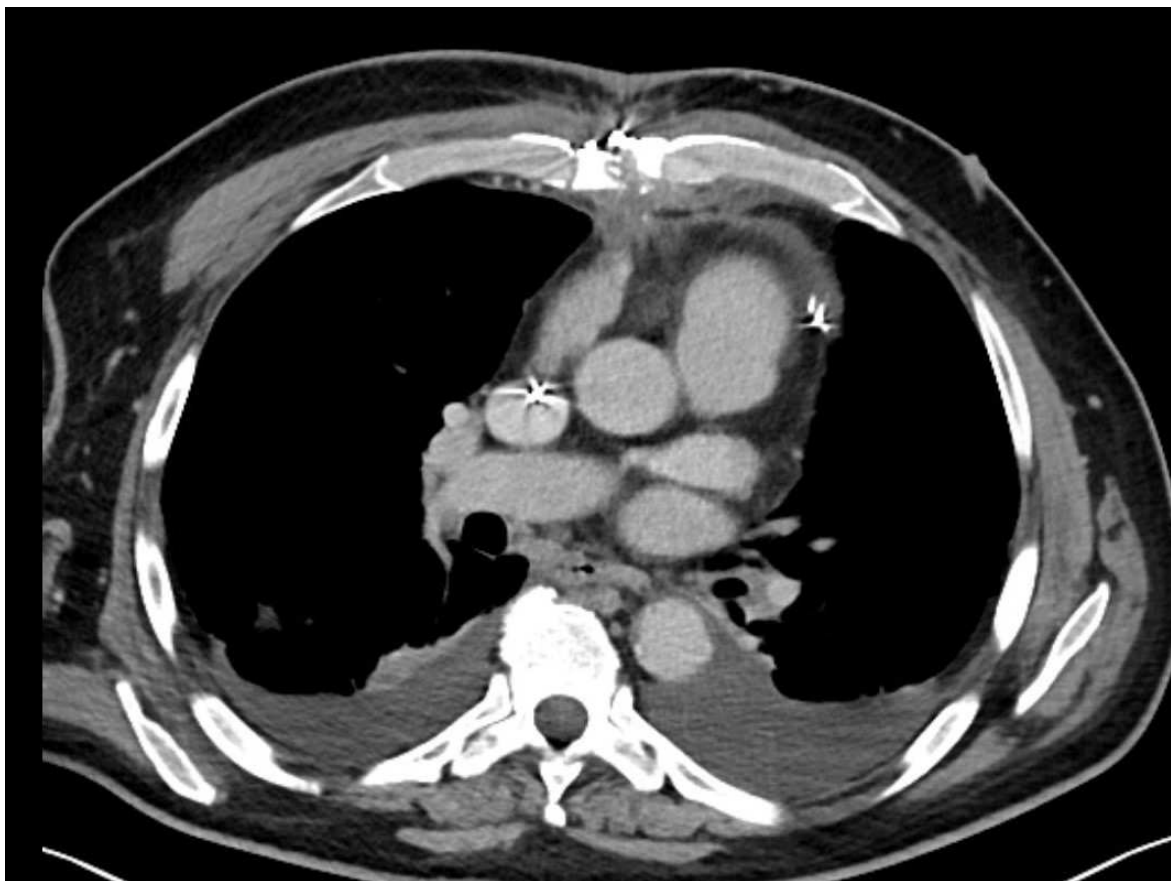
Chest CT axial view showing sternal dehiscence, retrosternal infiltration and pleural effusion on both sides. (Image Source: Wound clinic, Heart Centre Dresden)
